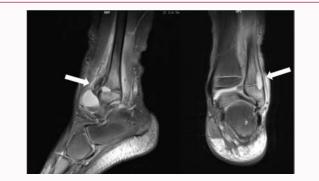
MRI of the patient's left ankle joint shows the local bone defect of the epiphyseal plate and epiphysis at the distal end of the fibula.
